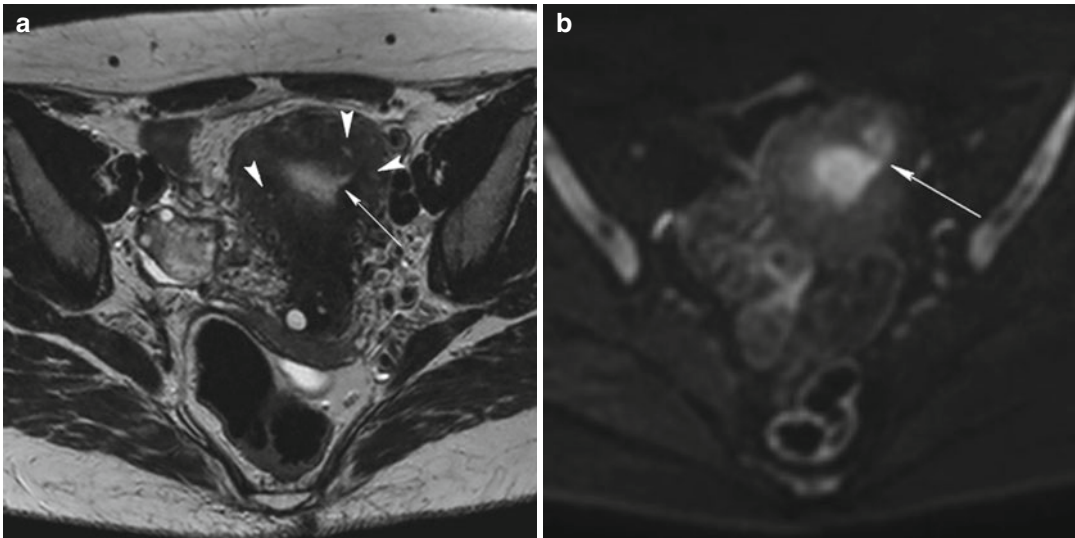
Adenomyosis. Adenomyosis is characterized by the presence of ectopic endometrial glands and stroma within the myometrium, which results on axial T2-weighted image (a) as various hyperintense signal foci in the myometrium (arrowheads). Benign invasion of the basal endometrium into the myometrium is shown as
